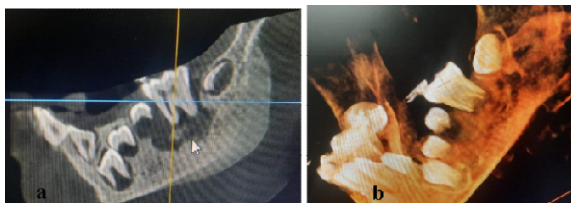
a) and b) Axial and cross sections in CBCT showing new bone formation and a tunnel-like defect in the vestibule cortical surface of the inflamed bone starting from the apical region of tooth number 36.
